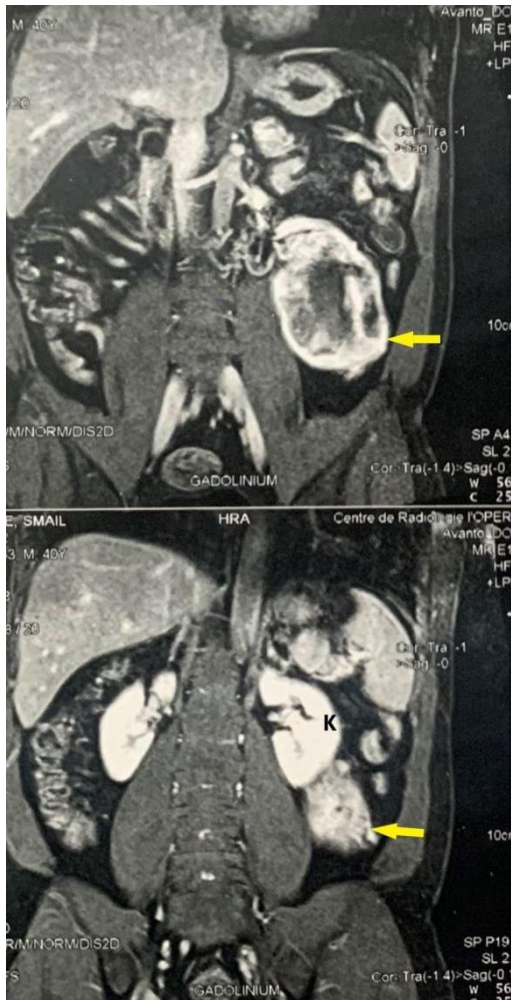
MRI image show the PGs (yellow arrow), with a close connection to the anterior pararenal space (K : the kidney)
